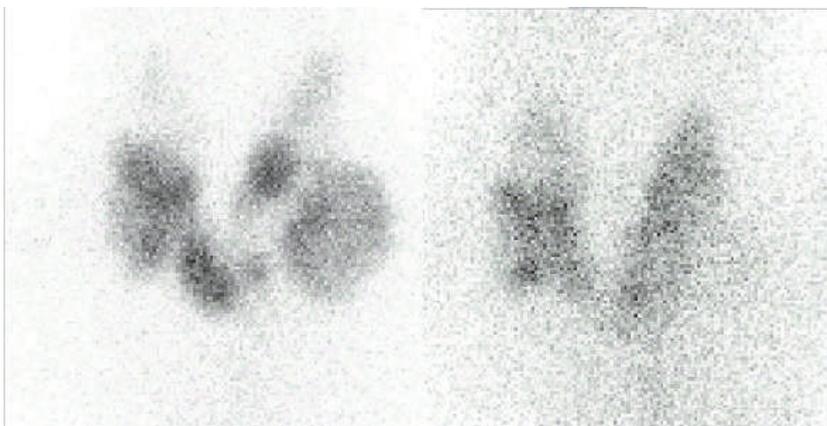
Thyroid scintigraphy - multifocal functional autonomy in multinodular goiter before (on the left) and after (on the right) successful RAIT
